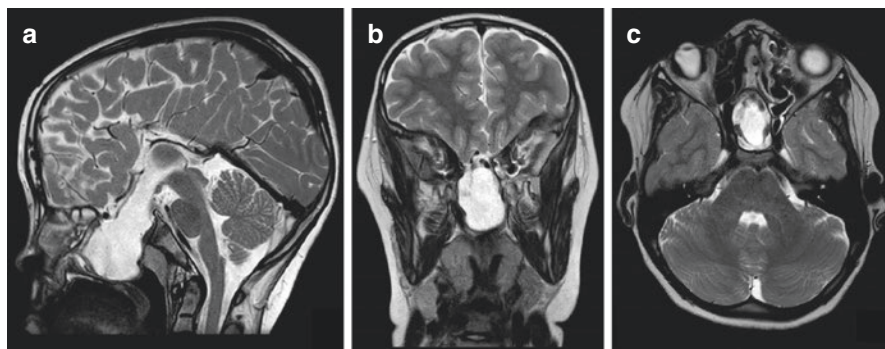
Magnetic resonance imaging (MRI) of a child with basal encephalocele (sphenothmoidal). (a) Sagittal section showing the cephalocele resting on the soft and hard palate. (b) Coronal view of the T2-weighted image. (c) Axial view of the MRI demonstrating the extent of the caudal herniation of the sac and its relationship with surrounding structures
